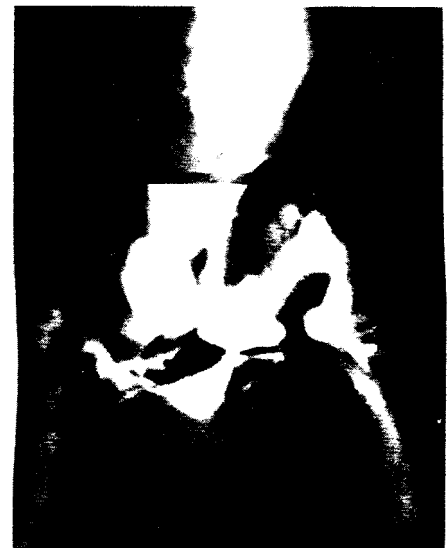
(A): CT dissecting abdominal aortic aneurysm with partial mural wall thrombosis.
